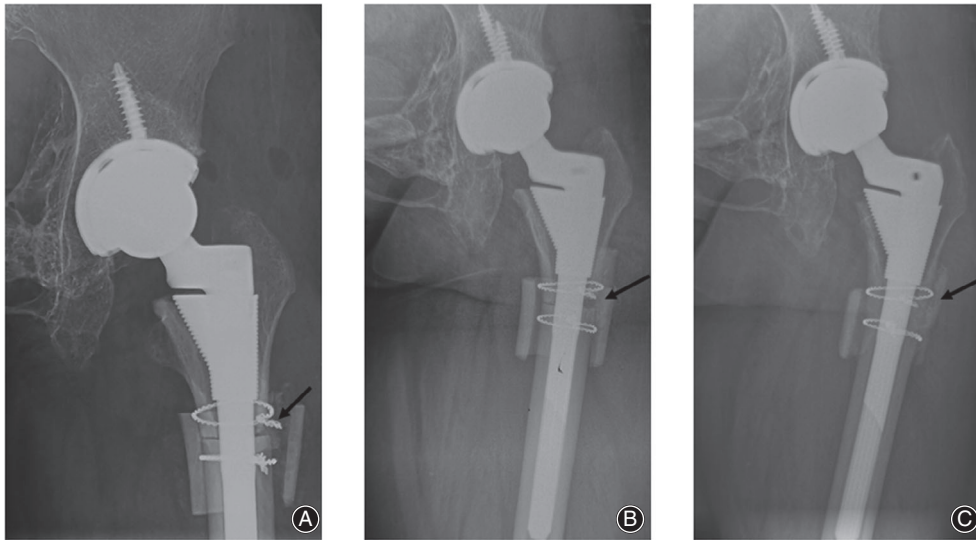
The radiographic changes of osteotomy gap after direct anterior approach total hip arthroplasty with STO. Anteroposterior radiography of left hip at 1st day (A), the 1st month (B) and 6th month (C) after surgery. The gap was indicated by black arrow.
